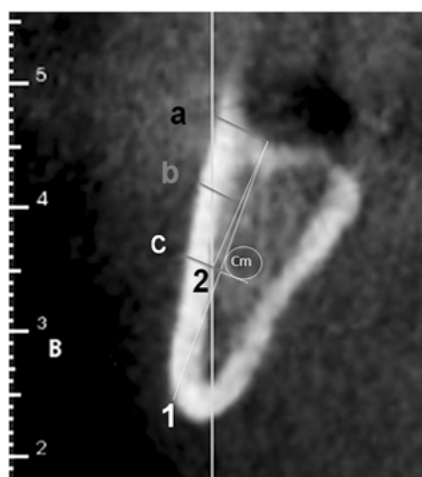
A) Transaxial slice view and radiographic anatomic upper segment - "A", middle segment - "B" and bottom segment - "C" distances (mm); B) Line 1 - line which defines the long mandible axis and is tangent to the vestibular cortical portion of the mandible canal; C) Line 2 - line from the bone ridge intersection with the line 1, ending on the bottom segment distance inner extremity.
